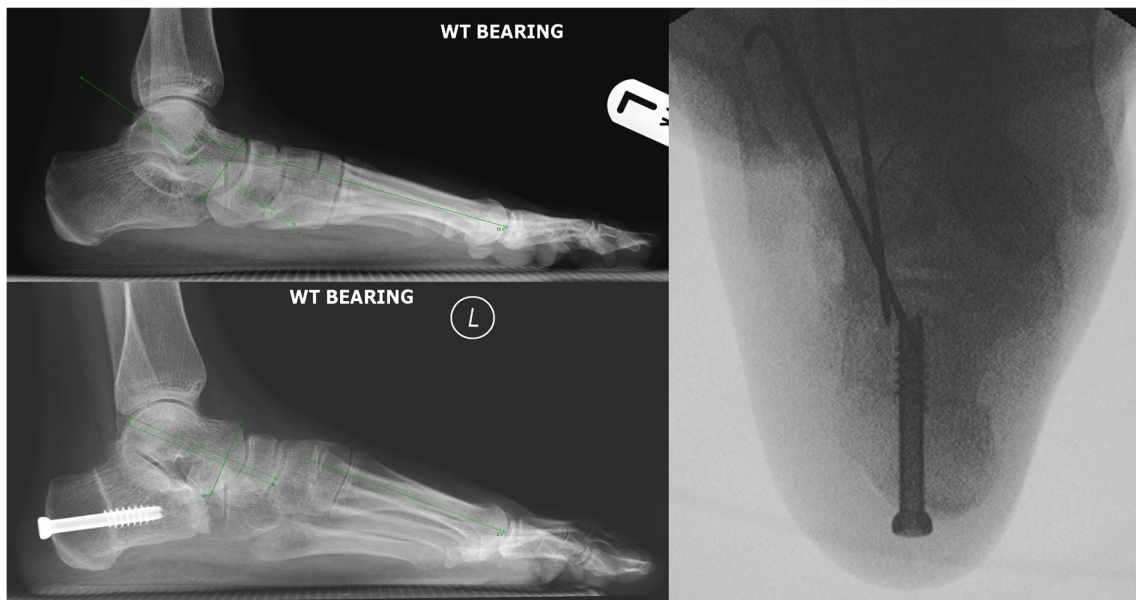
Patient A2. Top left, pre-operative weight-bearing lateral foot X-ray showing Meary's angle of -18.60° . Bottom left, post correction weight-bearing lateral foot X-ray showing Meary's angle of -2.30° (16.30°
